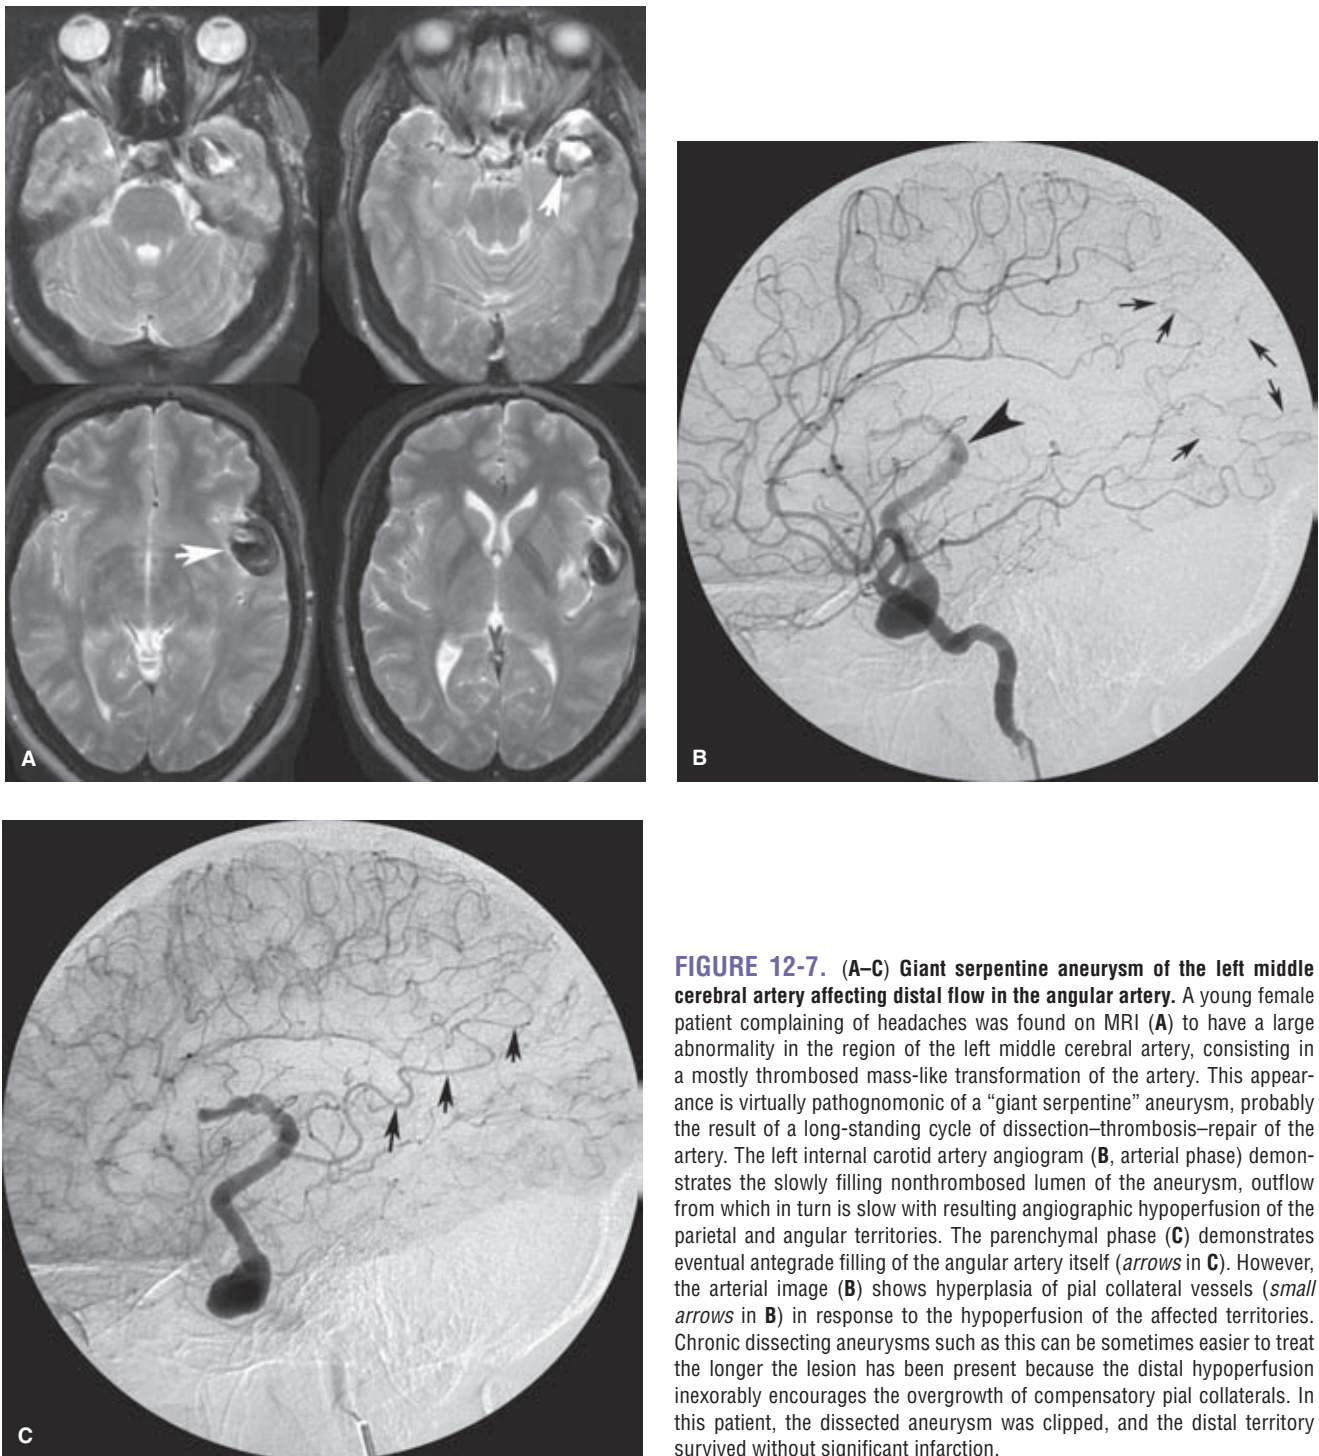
(A–C) Giant serpentine aneurysm of the left middle cerebral artery affecting distal flow in the angular artery. A young female patient complaining of headaches was found on MRI (A) to have a large abnormality in the region of the left middle cerebral artery, consisting in a mostly thrombosed mass-like transformation of the artery. This appearance is virtually pathognomonic of a “giant serpentine” aneurysm, probably the result of a long-standing cycle of dissection–thrombosis–repair of the artery. The left internal carotid artery angiogram (B, arterial phase) demonstrates the slowly filling nonthrombosed lumen of the aneurysm, outflow from which in turn is slow with resulting angiographic hypoperfusion of the parietal and angular territories. The parenchymal phase (C) demonstrates eventual antegrade filling of the angular artery itself (arrows in C). However, the arterial image (B) shows hyperplasia of pial collateral vessels (small arrows in B) in response to the hypoperfusion of the affected territories. Chronic dissecting aneurysms such as this can be sometimes easier to treat the longer the lesion has been present because the distal hypoperfusion inexorably encourages the overgrowth of compensatory pial collaterals. In this patient, the dissected aneurysm was clipped, and the distal territory survived without significant infarction.
